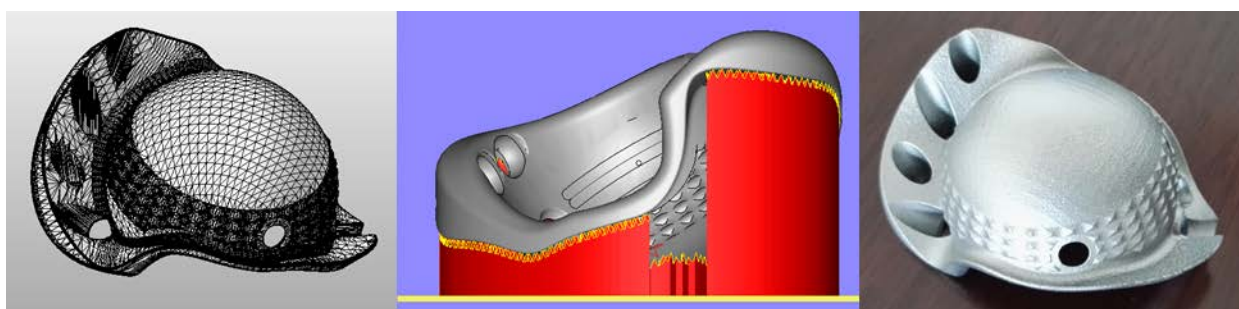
Patient data in the form of computed tomography (CT) scans or magnetic resonance imaging (MRI) scans can be used to create computer aided design (CAD) models, which can then be used to print custom implants. L-R this figure shows the initial design of a custom implant, the pre-print manipulation of the design including support structures in red and the final post-processed part.
